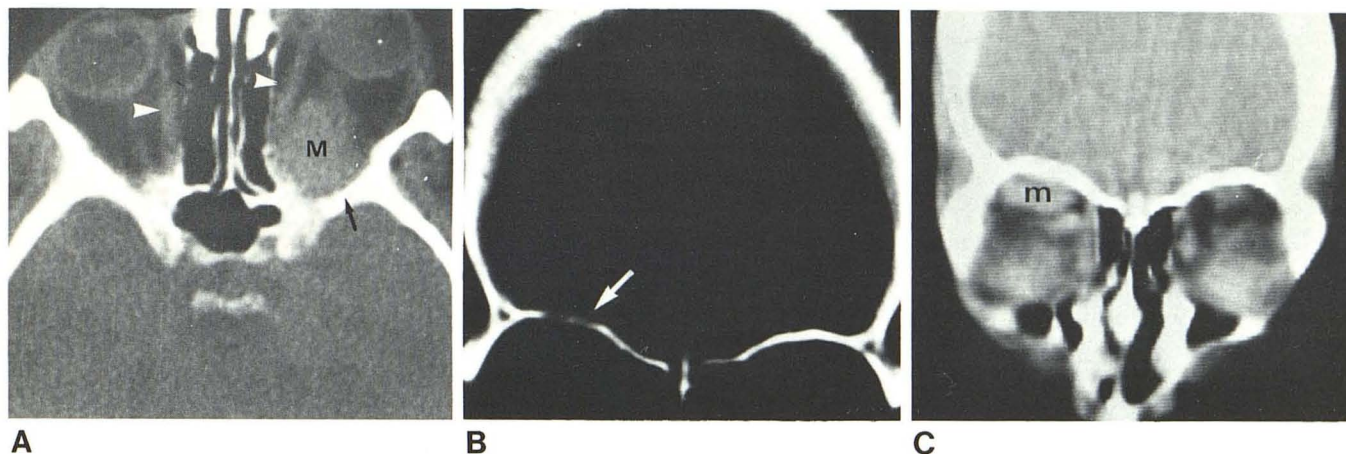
A, Axial CT scan with contrast. Slightly enhancing mass (M) in superoposterior right orbit. Moderate enlargement of both medial recti (arrowheads). Remodeling of posterior bony wall of right orbit (arrow). Obvious
